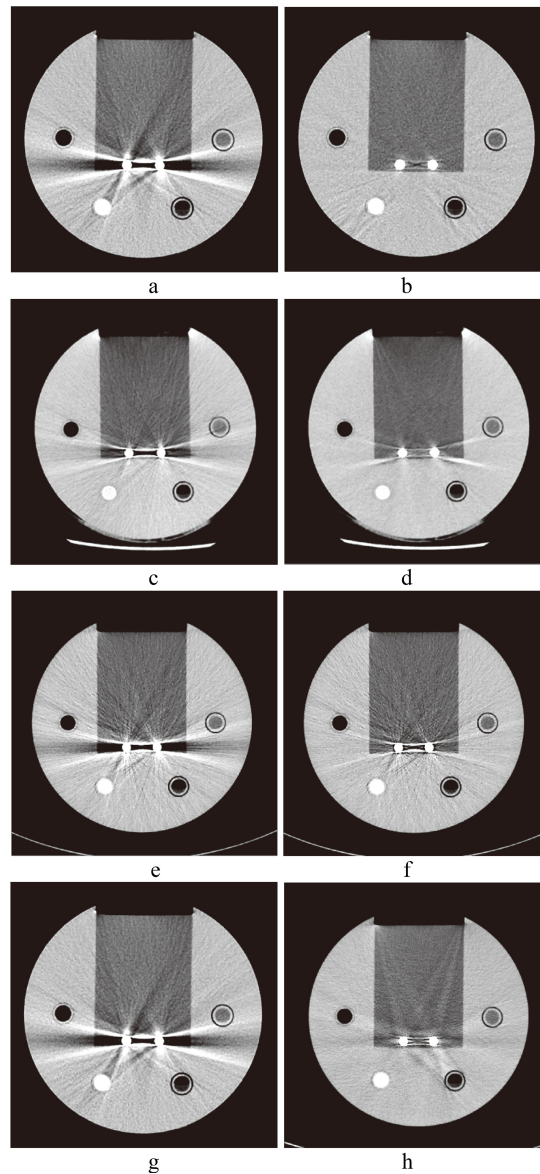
CT images of spinal implants. a. Image without SEMAR; b. with SEMAR. c. Image without Smart-MAR; d. with Smart-MAR. e. Image without IMAR; f. with IMAR. g. Image without OMAR; h. with OMAR.
